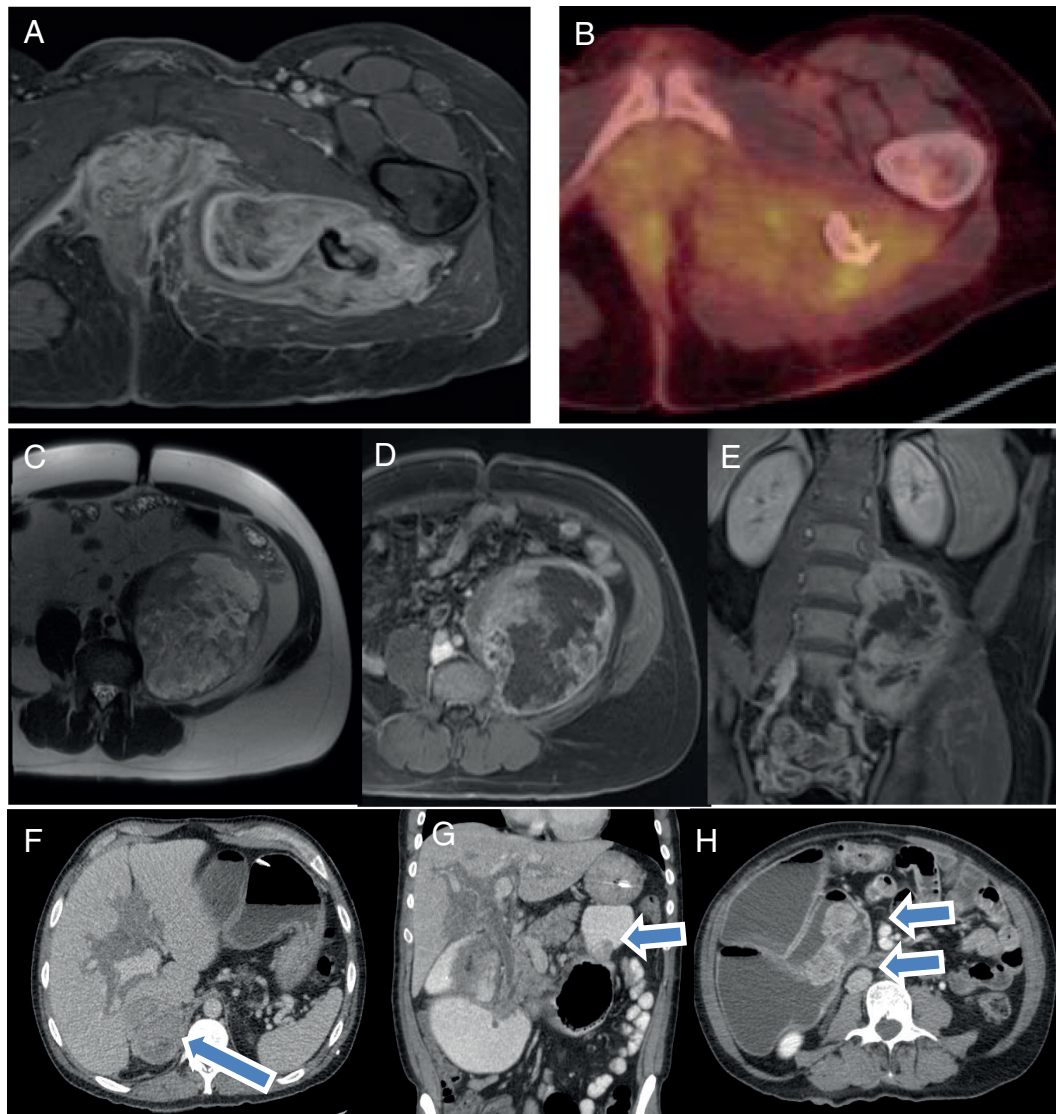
Imaging characteristics of abdominal neoplasms in NF1 patients. Axial postcontrast T1-weighted fat-saturated MR image demonstrates an infiltrative enhancing plexiform neurofibroma in the proximal left obturator region with components extending into the perineum and pelvic floor (A). Axial fused PET/CT image of the plexiform neurofibroma demonstrates low levels of FDG uptake with SUV_{max} 3.6–3.8; however, no definite areas for were suspicious for malignant transformation (B). Axial T2-weighted MR image demonstrates a heterogeneous mixed solid and cystic mass in the left retroperitoneum arising from the left L3 nerve root. Core biopsy was performed and pathology was consistent with malignant peripheral nerve sheath tumor (MPNST) (C). Axial and coronal postcontrast T1-weighted fat-saturated images demonstrate heterogeneous enhancement of the periphery and soft tissue components of the MPNST (D and E). Axial postcontrast CT image demonstrates a heterogeneous right adrenal mass in keeping with pheochromocytoma. There is also infiltrating low-attenuation soft tissue around the imaged portal structures (F). Coronal postcontrast CT image further demonstrates the infiltrating periportal soft tissue mass, in keeping with a plexiform neurofibroma. There is also patulous distension of the duodenum with oral contrast. In the proximal jejunum, there is a soft tissue mass in keeping with gastrointestinal stromal tumor (GIST) which was subsequently resected (G). Axial postcontrast CT image demonstrates routine surveillance of further intraluminal masses in the distended proximal duodenum, in keeping with further GISTs (H).
